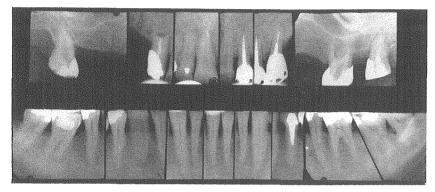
Roentgenograms of a case involving both periodontal and temporomandibular joint problems.
